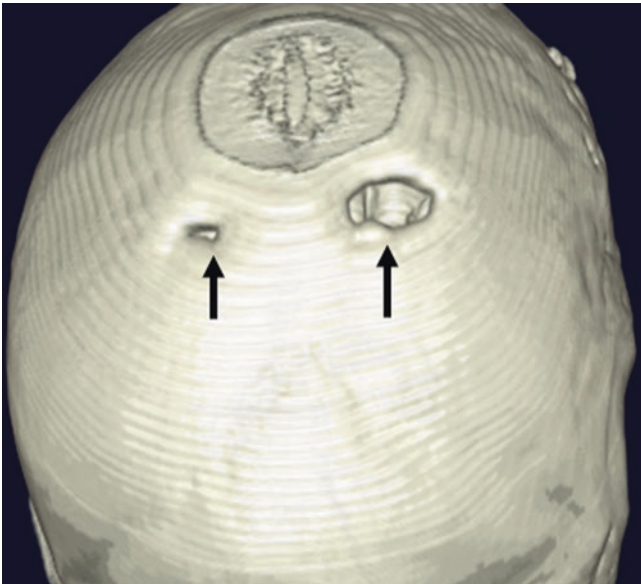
An 18 year old with asymmetric parietal foramina on axial (*left*) and 3D VR posterior view (*right*) images (note: the top of the head was not covered). Note a stair-step artifact from sequential CT acquisition
